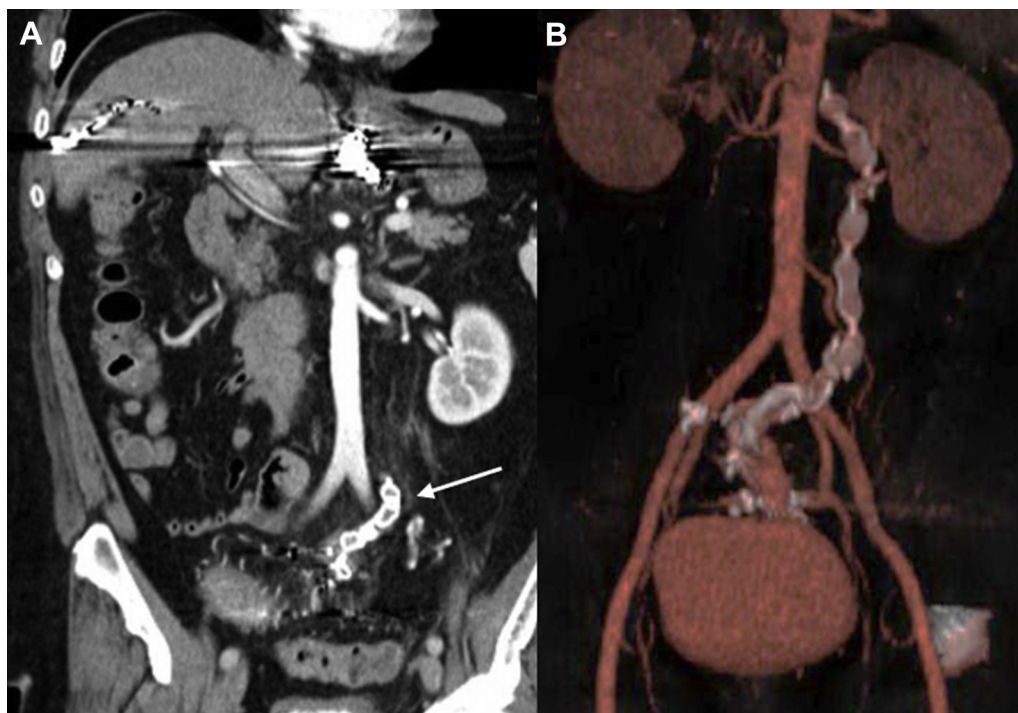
A, Computed tomography (CT) angiography shows no contrast material within the embolized inferior mesenteric vein (IMV) or downstream from the embolized inferior mesenteric artery (IMA). B, Three-dimensional reconstruction of segmental embolization of IMA and IMV.
